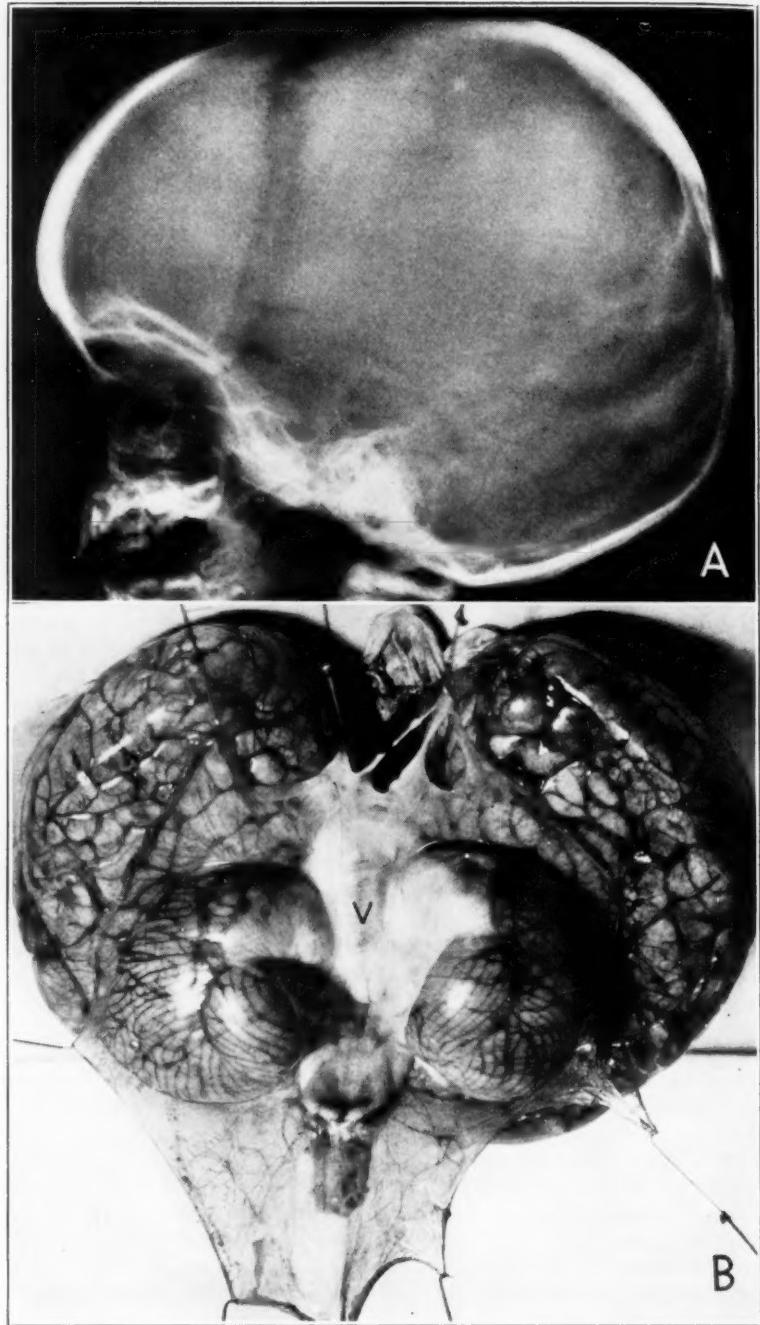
(case 2).—*A*, lateral roentgenogram of the skull, showing the position of the lateral sinus and torcular Herophili on the parietal bone. The diastasis of the sutures is apparent.
